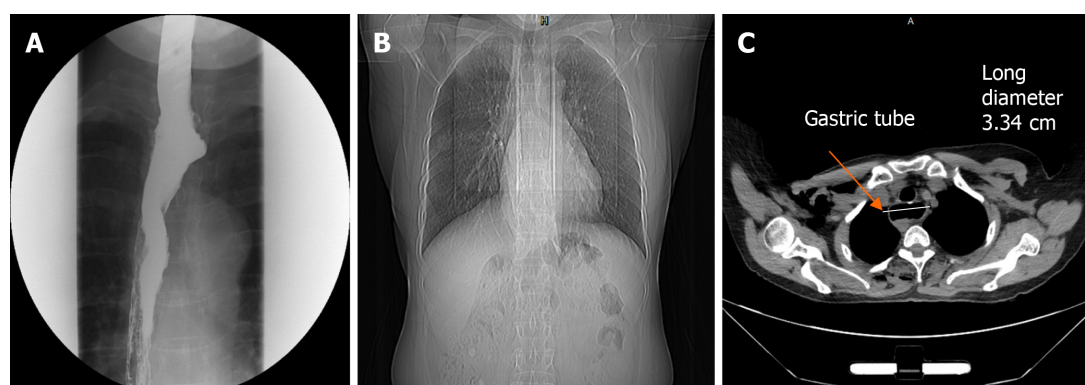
Preoperative examination. A: Preoperative esophagography showed patency of the reconstructed esophagus and no local fistula; B: Preoperative chest computed tomography showed right lung lower lobe nodules with no active lung lesion; C: Preoperative chest computed tomography showed gastric tube mild dilatation.
